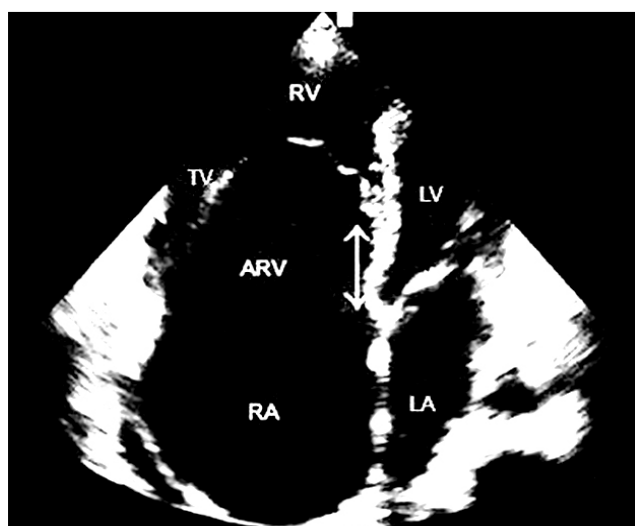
Apical 4-chamber, 2-dimensional echocardiogram shows displacement of the tricuspid valve toward the apex of the right ventricle.
